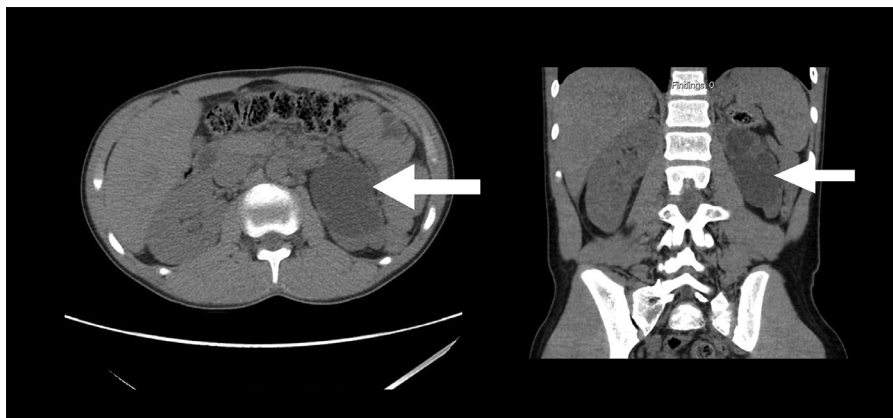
Axial (left) and coronal (right) images from the computed tomography study showing severe hydronephrosis of the left kidney. Arrows denote the dilation of the renal pelvis as seen in hydronephrosis.
